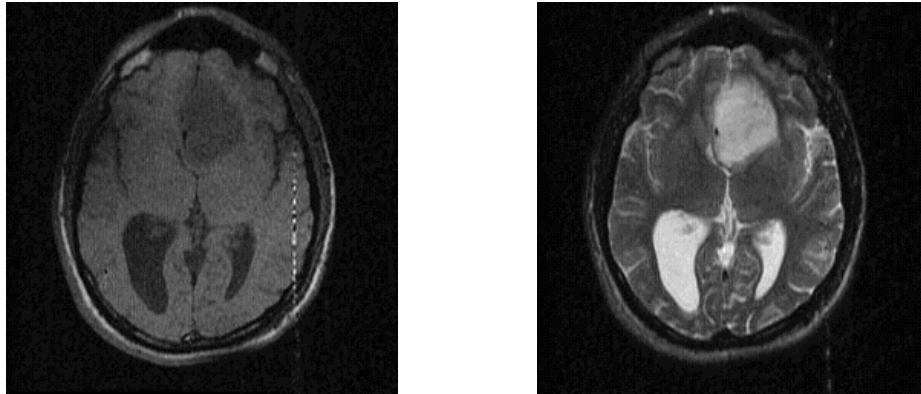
Extensive left frontal low-grade glioma. Left: T1-weighted image, showing a hypointense frontal tumor mass. Right: T2-weighted image at the same level. The lesion shows up as hyperintense.
